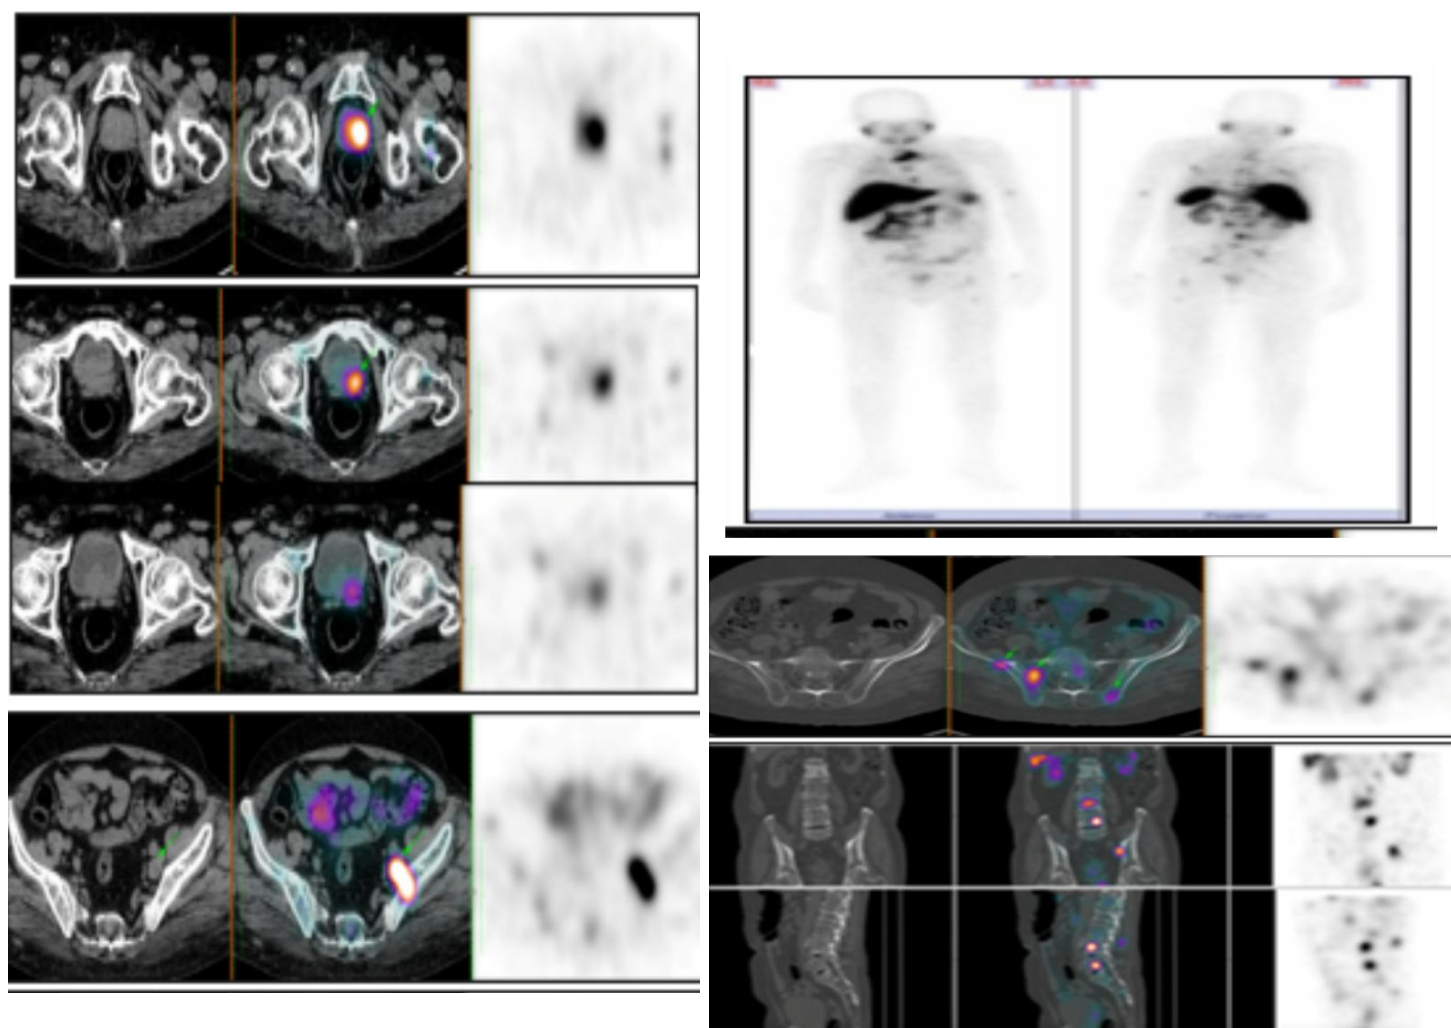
99mTc PSMA SPECT/CT trans axial view(abdomen window)(A) trans-axial, coronal and sagittal views(bone window) (B) of the pelvis and planar anterior and posterior view (c) show PSMA avid prostatic lesion involving the transitional and peripheral zone of the gland at the left side with infiltration of the left seminal vesicle and urinary bladder wall.
